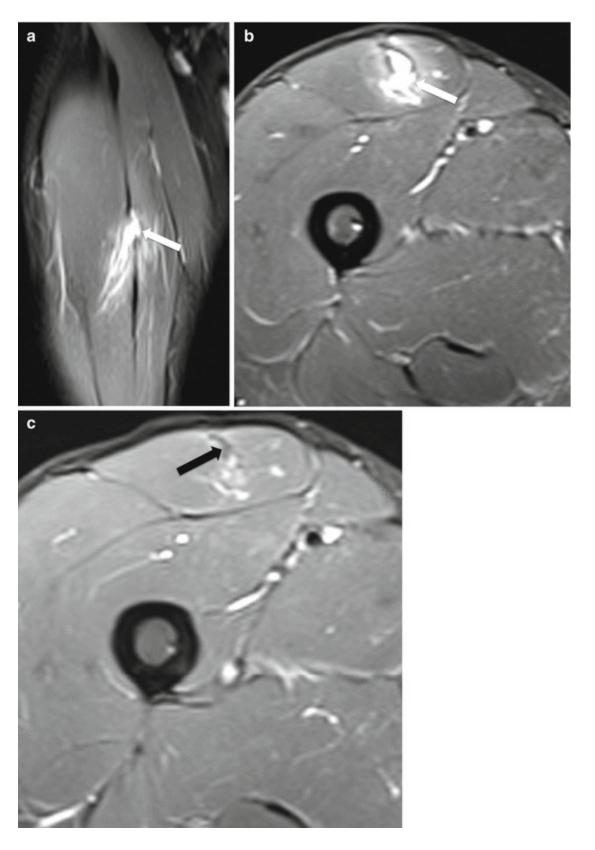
A 25-year-old male athlete with a central myotendinous injury of the right rectus femoris. (a) Coronal and (b) axial fat-suppressed T2-weighted MRI show a partial tear of the deep myotendinous junction of the rectus femoris associated with fluid collection (*arrow*). (c) Axial fat-suppressed T2-weighted MRI performed 10 months later show resolution of the hematoma and low-signal thickening of the deep tendon consistent with a fibrous scar (*arrow*)
